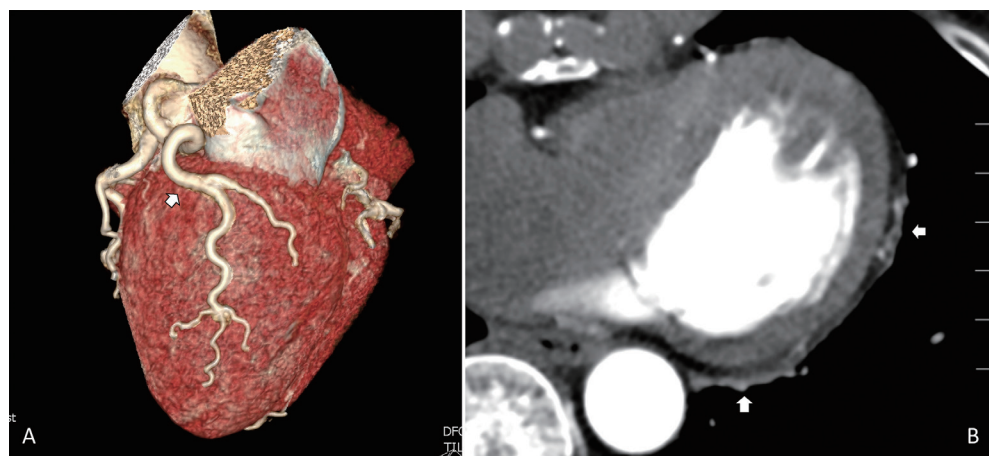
The computed tomography coronary angiography.
